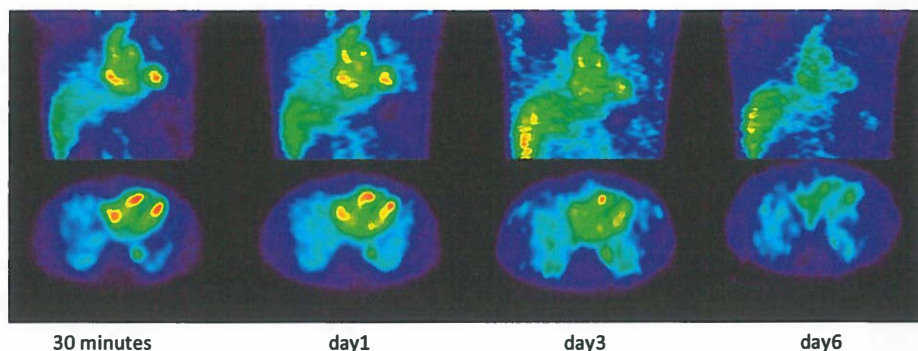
Coronal and transversal SPECT images of the chest and upper abdomen 30 minutes and 1, 3 and 6 days post-injection of ^{111}In -mapatumumab. Physiological ^{111}In -mapatumumab uptake is seen in predominantly the heart, the descending aorta and the liver. No tumor lesions are visible in these images.
